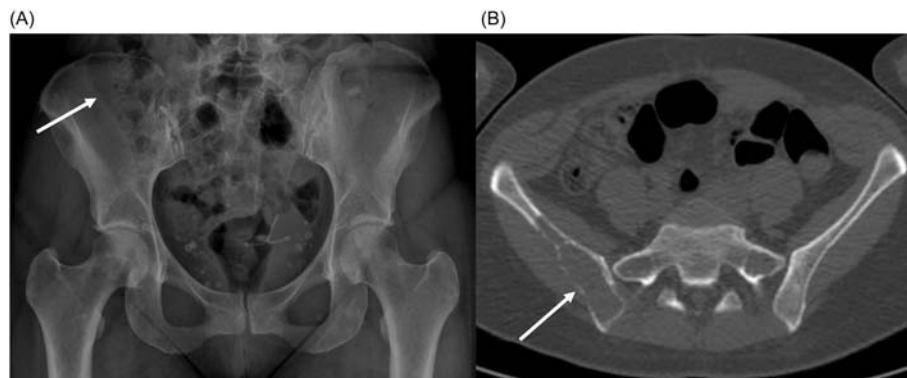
Pelvic X-ray film (A) and CT (B) in a patient with multiple myeloma. On CT, a large destructive lesion in the iliac bone (*arrow*) is easily detected and was originally missed on plain films. Retrospectively, one can discriminate the vertical contour of the lesion (*arrow* in A), but it was obscured by overlying bowel gas.
